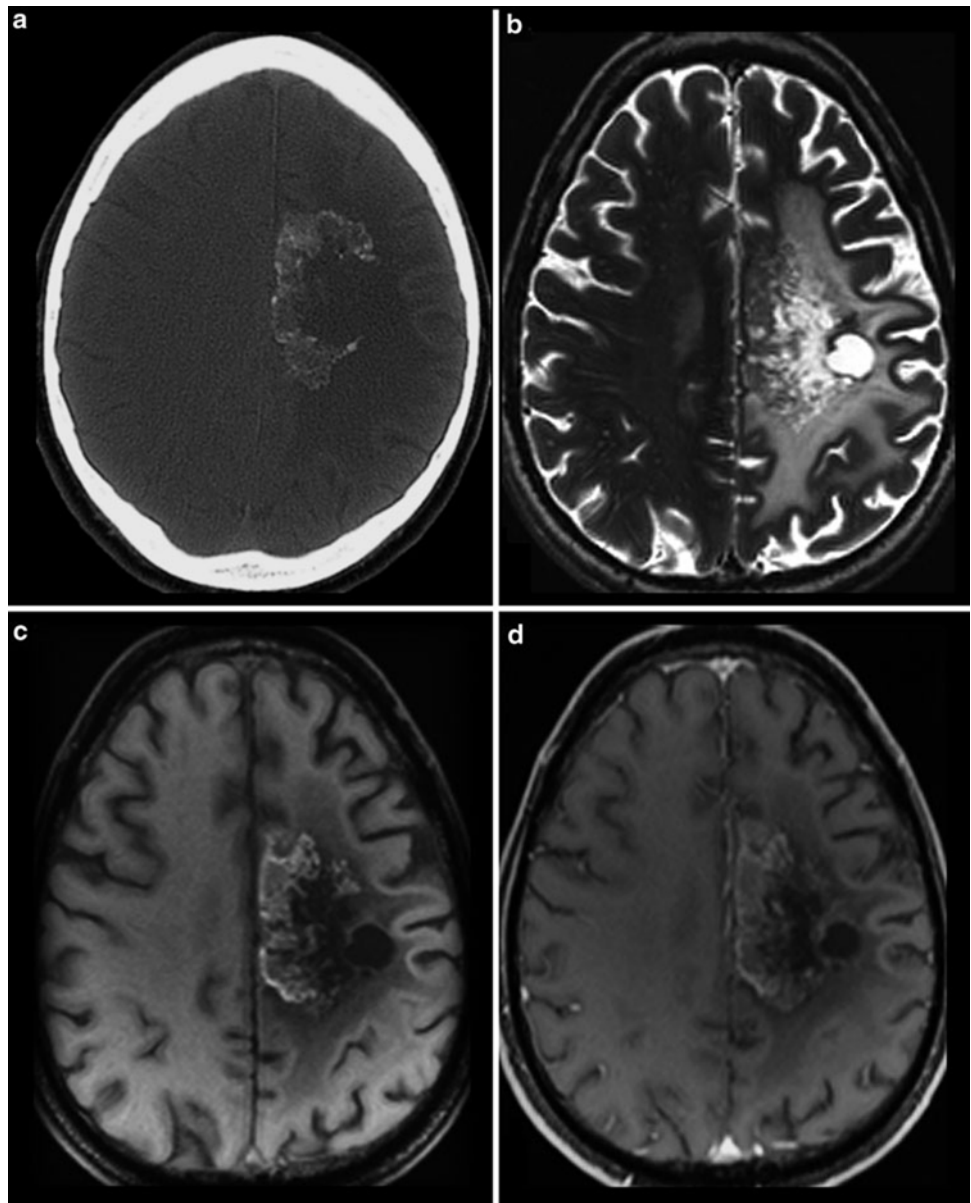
CCT (a) and MRI (b–d) of a patient treated with antiangiogenic drug. CT yields calcifications in the tumor area which are also hyperintense in the precontrast MRI (c). Therefore, precontrast T1WI should be always considered because otherwise these hyperintense areas may be misinterpreted as enhancing areas (see also Fig. 17)
